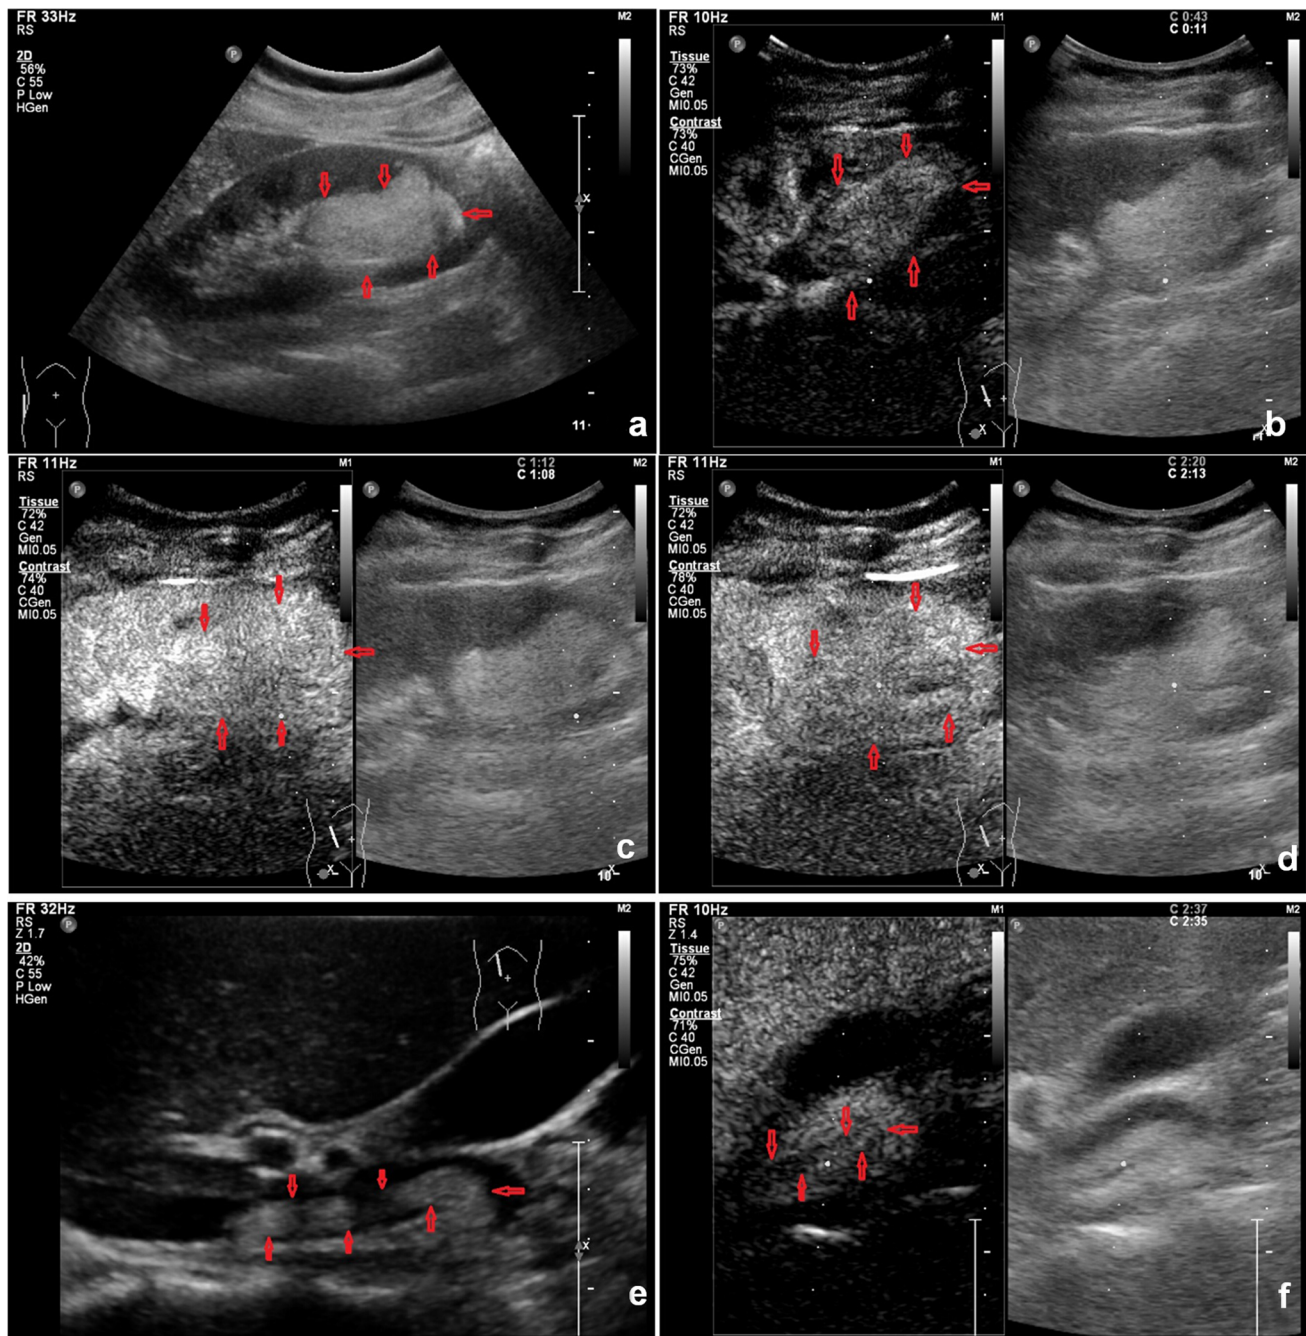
B-mode ultrasound images. a A 5.0 × 3.2-cm hyperechogenic mass occupying the inferior pole of the right kidney. e Extension of the mass into the RRV and IVC. Contrast-enhanced ultrasound images. b The mass was heterogeneously hyperenhanced compared to
